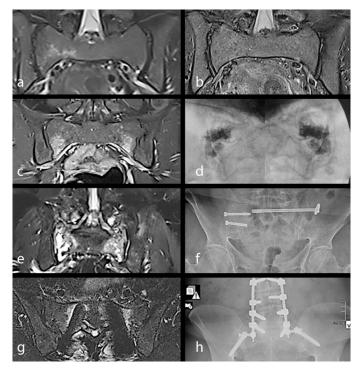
Coronal T2-weighted (T2W) short tau inversion recovery (STIR) sequence demonstrating hyperintensity located within the right sacral ala (a). The fracture is healed with conservative treatment (b). Hyperintensity in coronal T2W STIR sequence suggestive of bilateral sacral alar fracture (c). Percutaneous sacroplasty achieves functional improvement (d). Bilateral alar fractures are seen as hyperintensity zones on MRI (e) are treated successfully by bilateral percutaneous sacroiliac fixation (f). Sacral stress fracture accompanying lumbosacral instrumentation (g) can be treated with lumbopelvic fusion (h)
